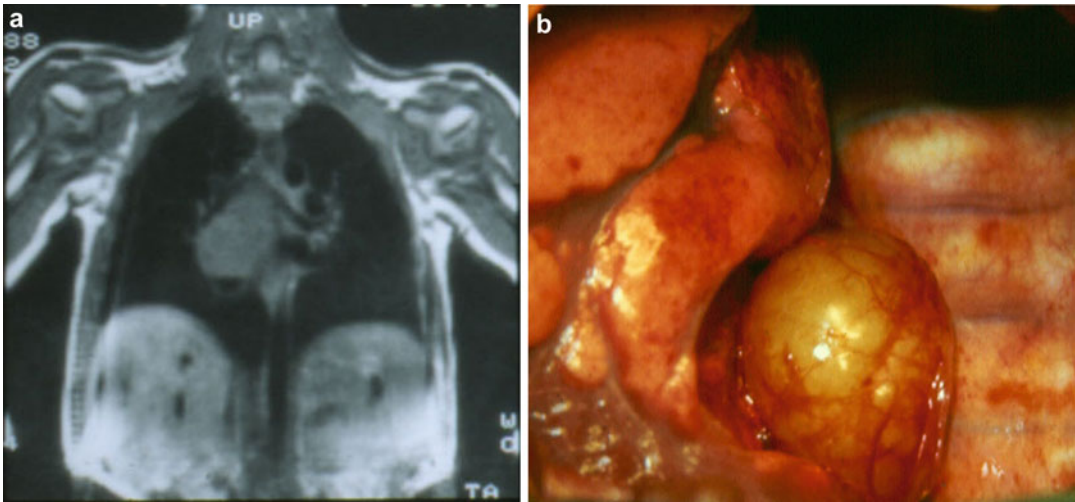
(a) MRI demonstrating a right-sided bronchogenic cyst just below the right main bronchus. (b) Thoracotomy
